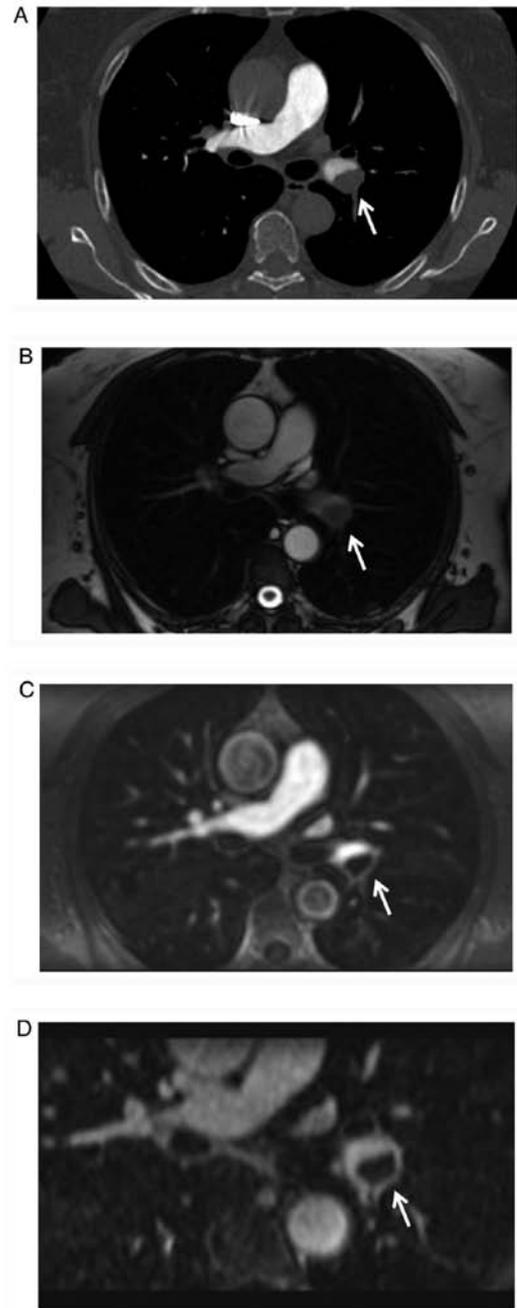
Pulmonary embolus in the left lower lobe in a 65-year-old male who presented with leg swelling for five days. After CTPA scanning, this patient displayed mild allergic reactions to the iodine contrast material, with symptoms including nausea, sweating and itchy skin, but he displayed with no allergic reactions to MR gadolinium-based contrast material. The embolus was visualized by (A) CTPA, (B) true fast imaging with steady-state precession, (C) contrast-enhanced MR pulmonary angiography and (D) enhanced volume-interpolated body examination, all of which depicted the lesion clearly (arrows) in the axial images. CTPA, computed tomography pulmonary angiography.
